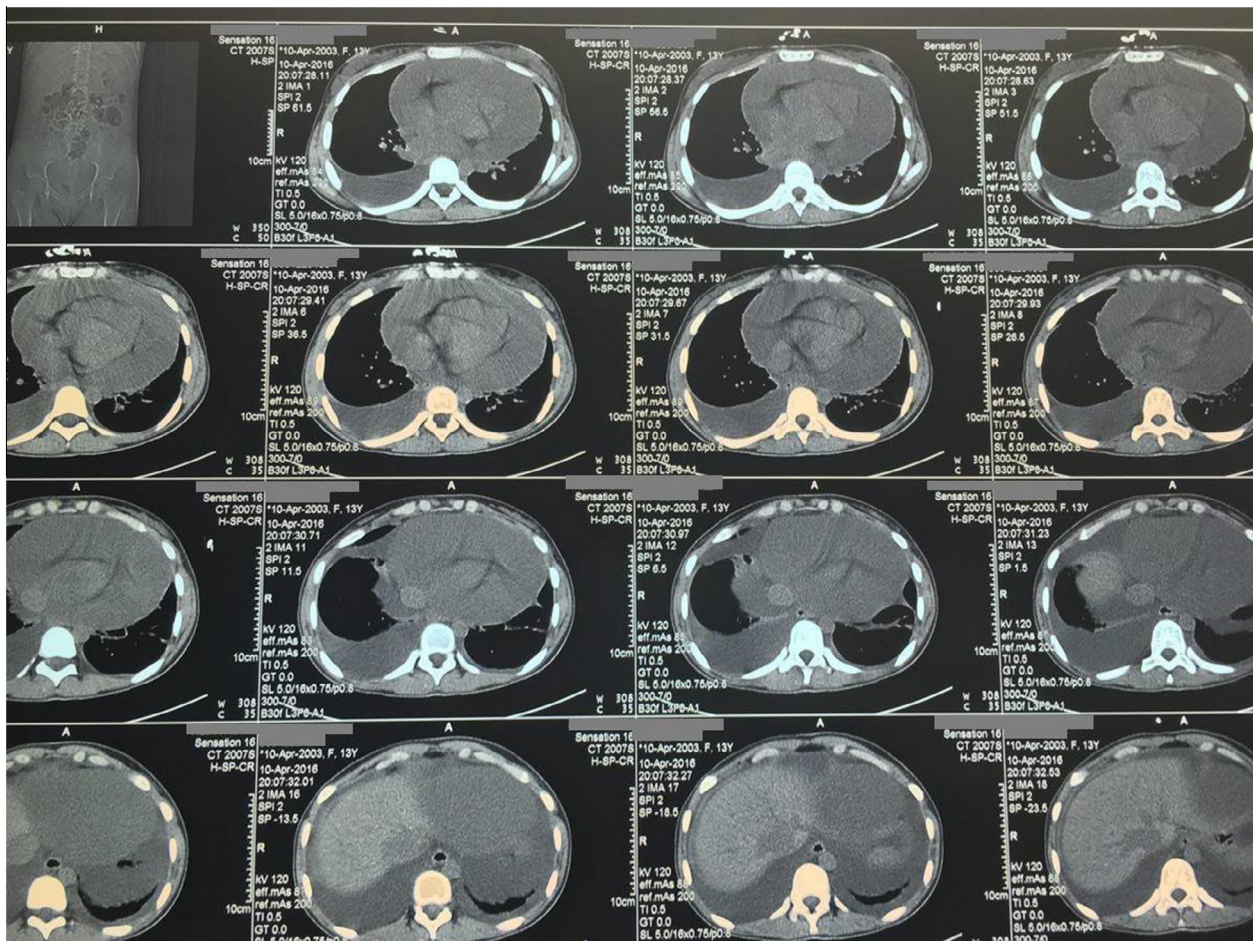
Abdominal and pelvic computed tomography scan with intravenous and oral contrast showing moderate ascites, right-sided pleural effusion, and massive pericardial effusion.
